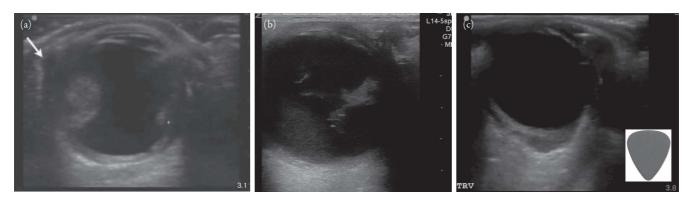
(a) Globe rupture with flattening of the anterior chamber, loss of spherical shape of globe, internal echoes, scleral buckling (white arrow) and retinal hemorrhage (*). Adapted from Figure 2 of Kilker BA, Holst JM, Hoffmann B. Bedside ocular ultrasound in the emergency department. Eur J Emerg Med. 2014;21(4):246–253. doi:10.1097/MEJ.00000000000000000. (b) Vitreous hemorrhage with "washing machine" sign. See Video 12.2. (c) Retrobulbar hemorrhage with "guitar pick" sign and deformation of the posterior globe.
